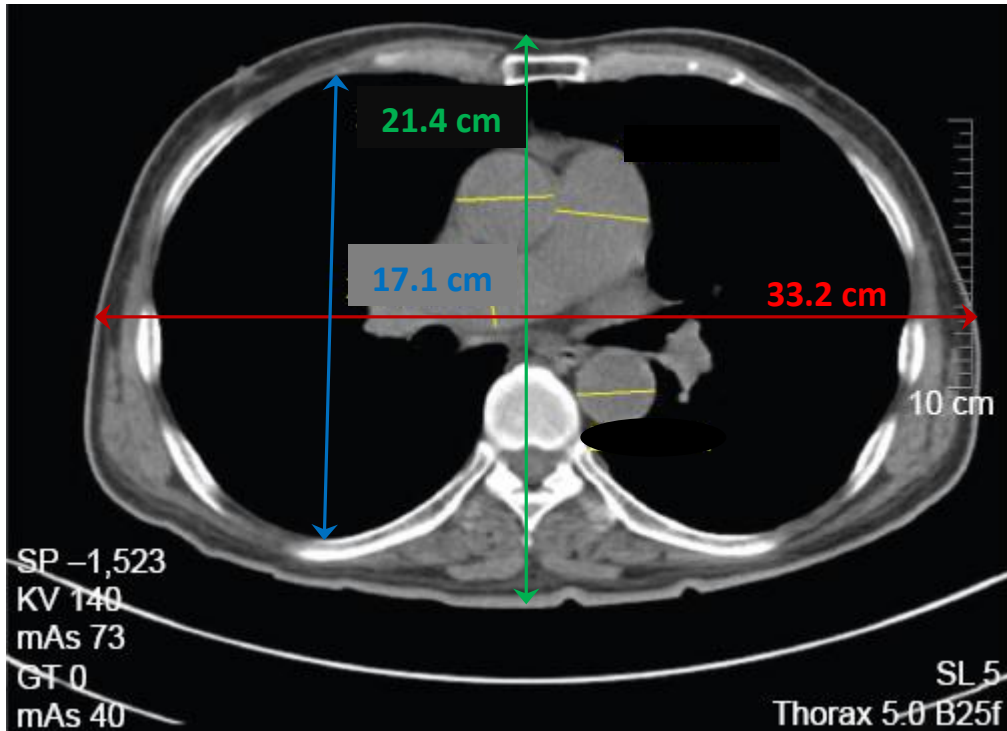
Transverse plane CT image of a human thorax at T-5 level, source (Chen et al., 2015).
